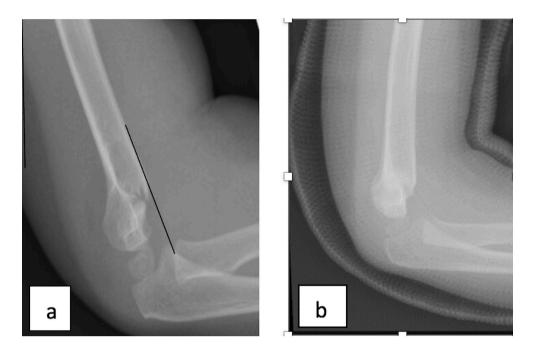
a) Lateral radiograph showing type IIA fracture (AHL not intersecting capitellum). b) Lateral radiograph showing loss of reduction following closed reduction and casting
